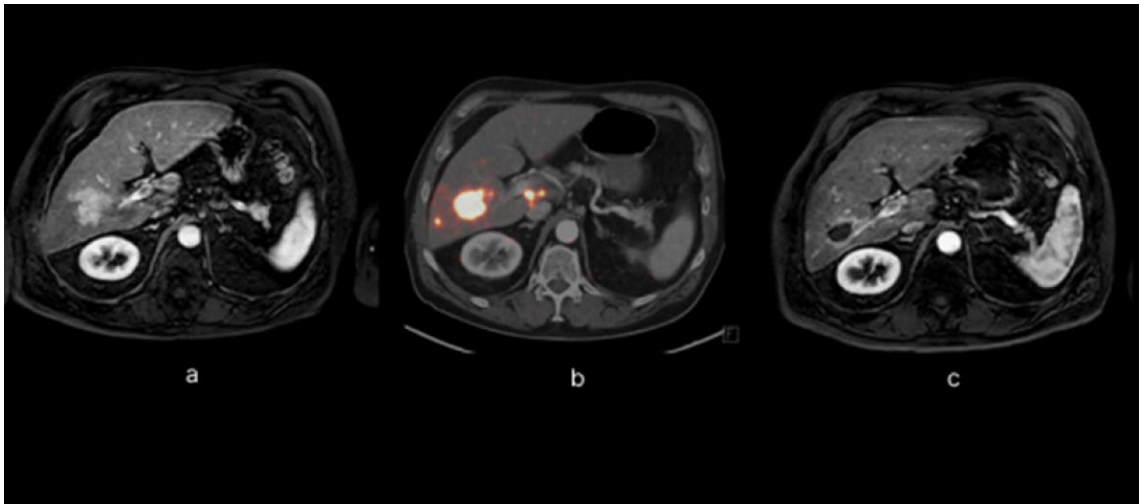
Patient with HCC who received radioembolization with ^{90}Y glass microspheres. (a) The baseline image (MRI) demonstrated enhancing hepatocellular carcinoma in segment V/VI. (b) PET/CT image immediately after the treatment, ^{90}Y glass microspheres were selectively injected into the right hepatic artery. As shown, the microspheres are homogeneously distributed in the tumor located in segment V/VI. (c) Follow-up MRI 2 months after radioembolization showing complete response to the treatment as the tumor is no longer enhanced.
